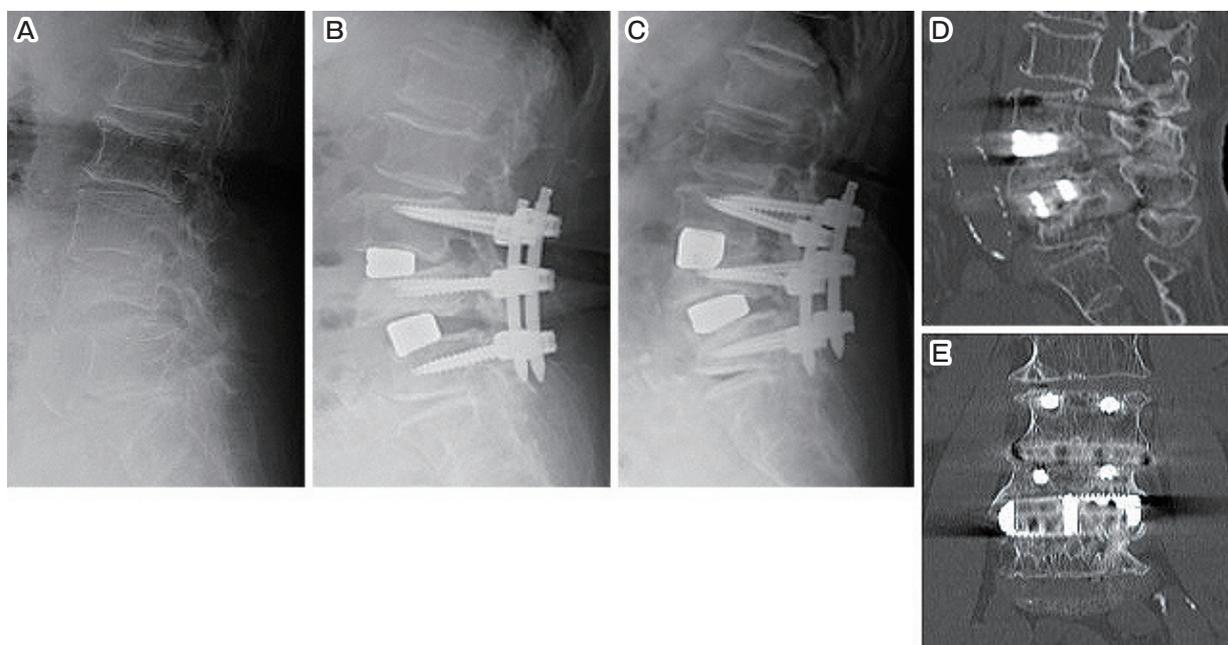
Plain radiography and CT scans of an 87-year-old female with L4 vertebral fracture.
